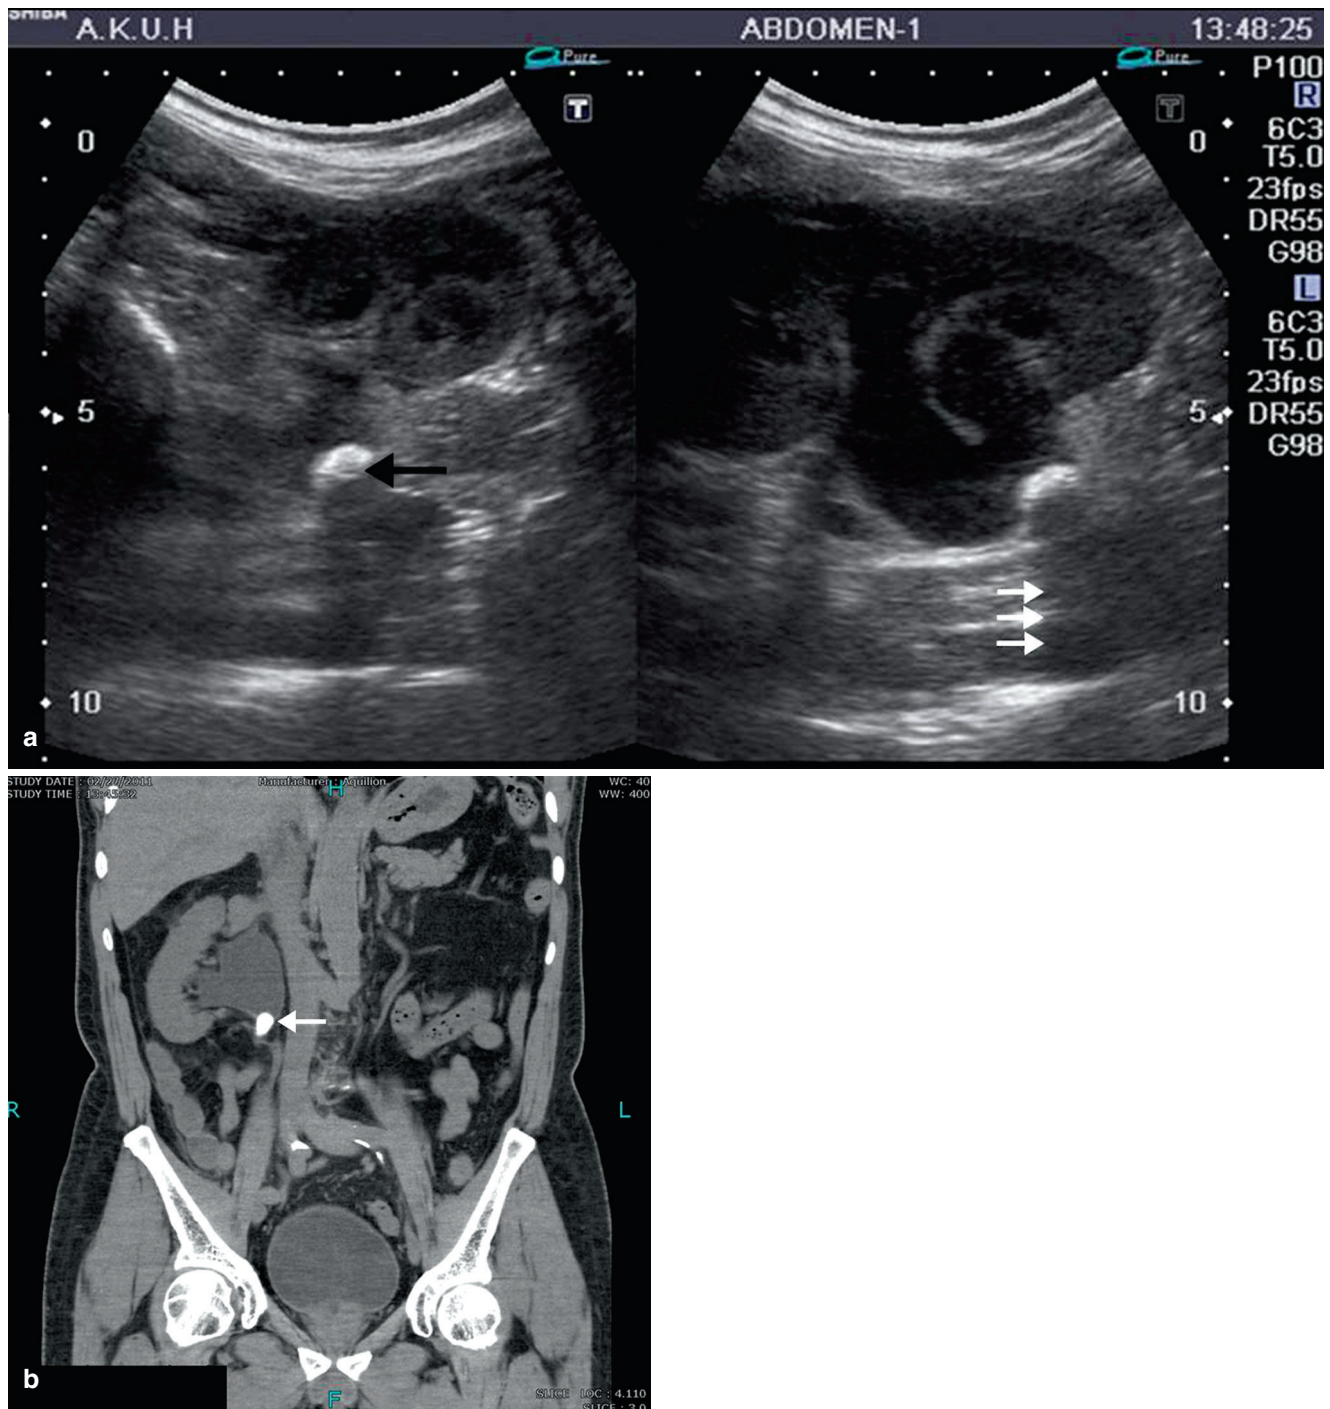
(a) Ultrasound of the kidney showing a calculus impacted at the pelvi-ureteric junction (*black arrow*) with posterior echoic shadowing (*white arrows*) with resultant hydronephrosis. (b) Coronal reformatted computed tomography (CT) scan showing a calculus (*white*
